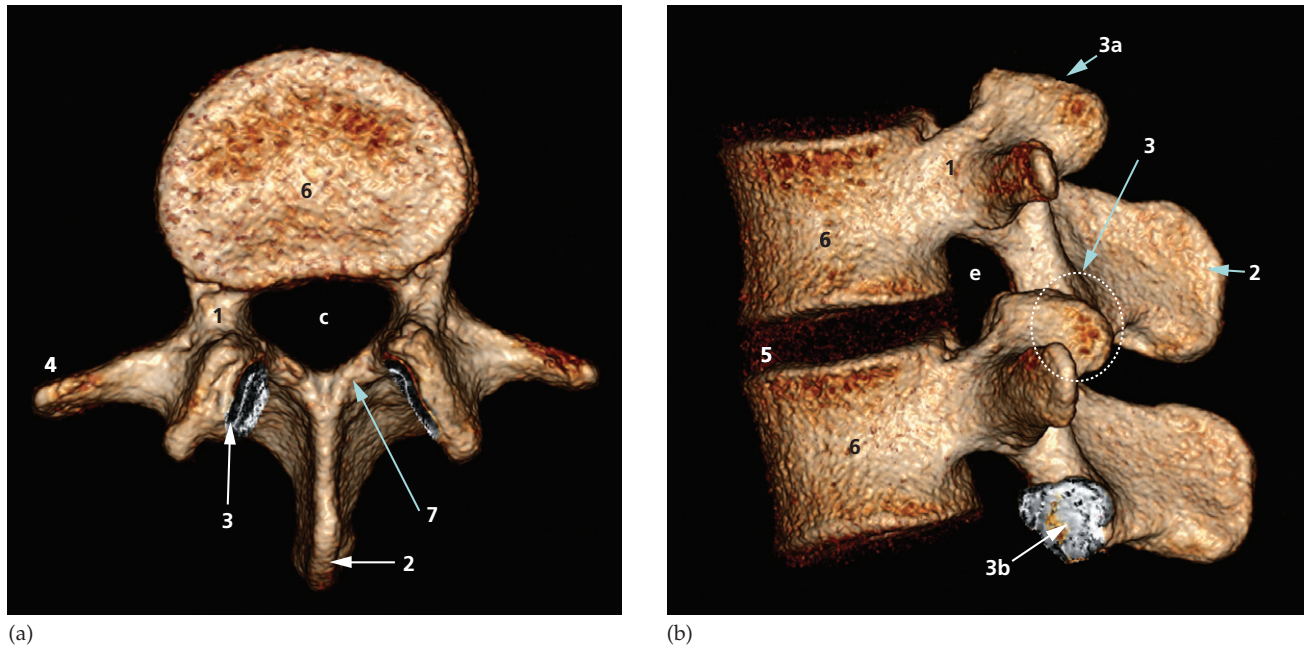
Normal vertebral anatomy. Surface-shaded CT reconstructions of lumbar vertebrae in (a) axial and (b) sagittal views. 1, pedicles; 2, spinous process; 3, facet joint made up of superior (3a) and inferior (3b) articular facets; 4, transverse process; 5, disc space; 6, vertebral body; 7, lamina; c, central canal; e, exit foramen.
